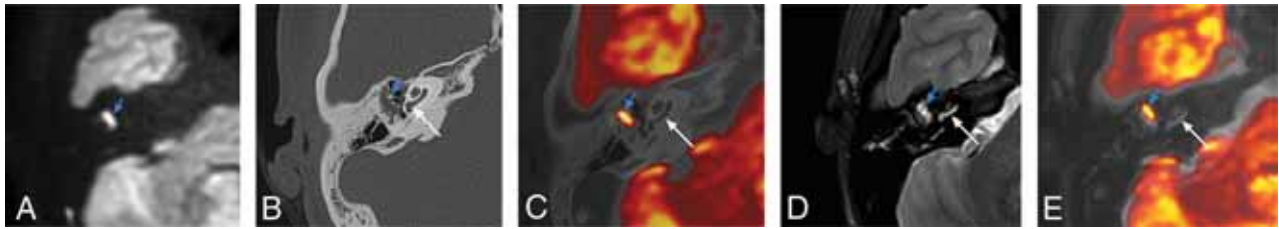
Surgical confirmation of a cholesteatoma in the tympanic cavity. *A*, TSE-DWI: a clear high-intensity-signal area (blue arrow) with a clear border in the right middle ear. *B*, HRCT: soft-tissue density shadow (blue arrow) in the middle ear with an unclear border and clear cochlear structures (yellow arrows). CT-DWI fusion image (*C*) clearly shows the cholesteatoma in the tympanic cavity. *D*, T2WI shows a nonspecific high-intensity-signal shadow in the mastoid process of the right middle ear. *E*, T2WI-DWI shows a clear cochlea with the cholesteatoma, localized in the tympanic cavity with reddish-yellow changes.
